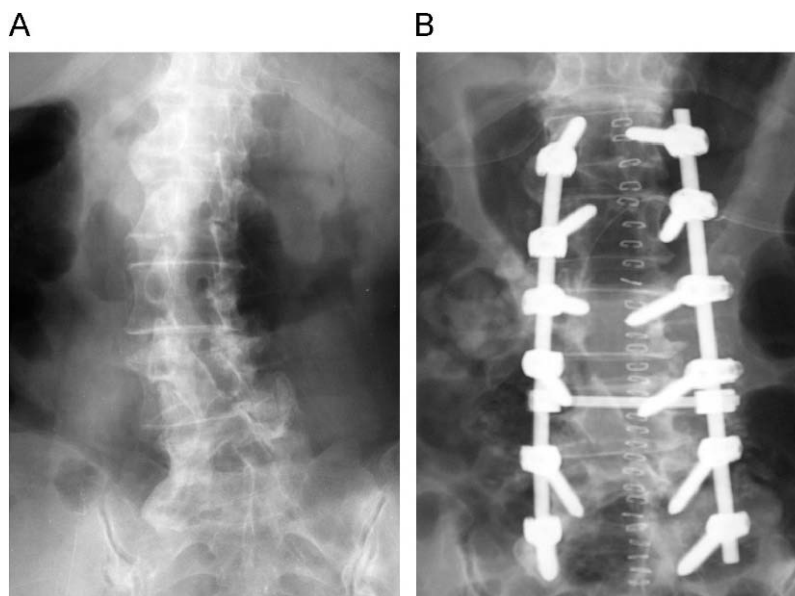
A) Post-operative anteroposterior x-ray. B) Post-op x-ray showing an external extrapedicular course of the screw at the second left lumbar vertebra.
